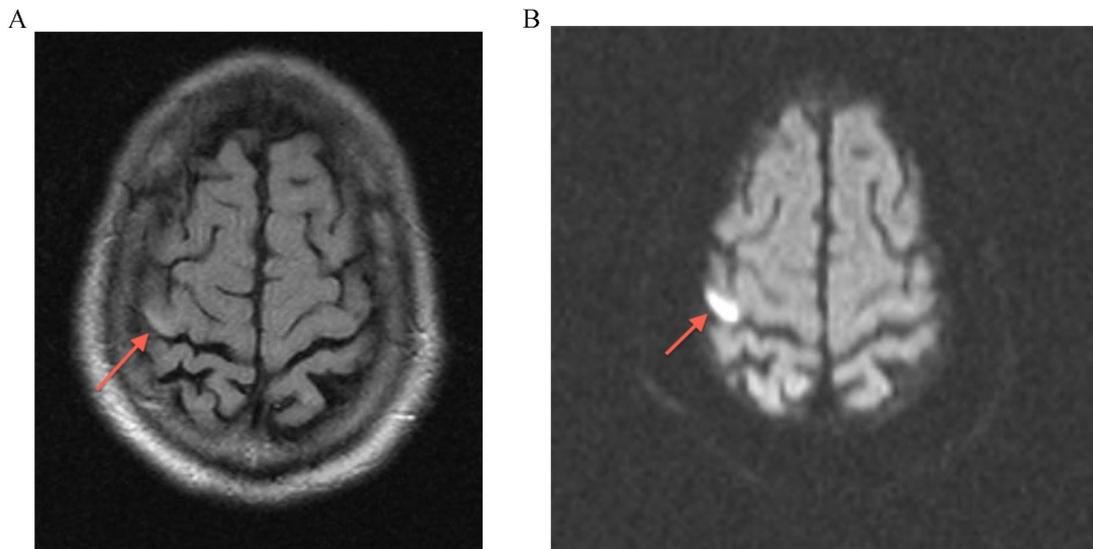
Brain MRI. (A) Axial flair image, and (B) Axial DWI diffusion series, both showing acute stroke in primary motor cortex.
